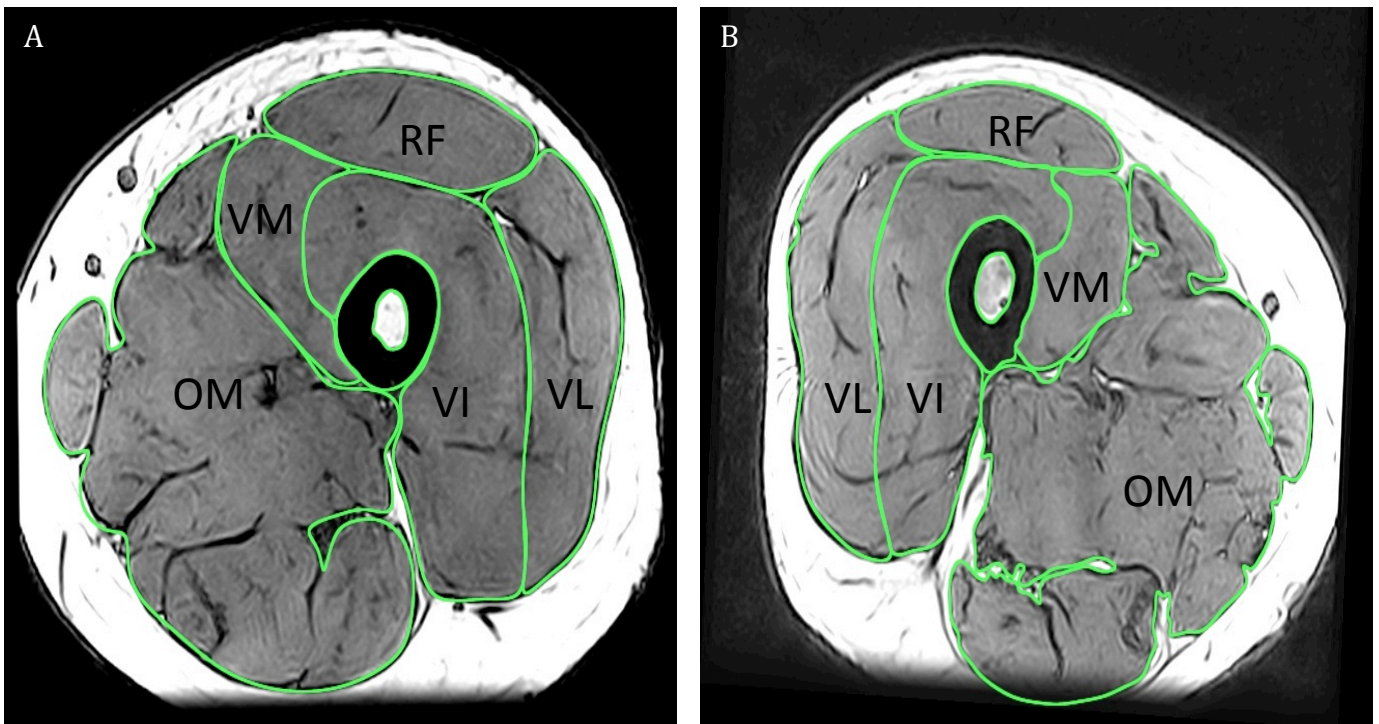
Magnetic Resonance Image of the thigh of A, a young man (22 years) and B, an older man (76 years) at 60% of femur length. Highlighted are the cross-sectional areas of the femur, RF, rectus femoris; VL, vastus lateralis; VI vastus intermedius; VM, vastus Medialis and OM Other Muscles.
